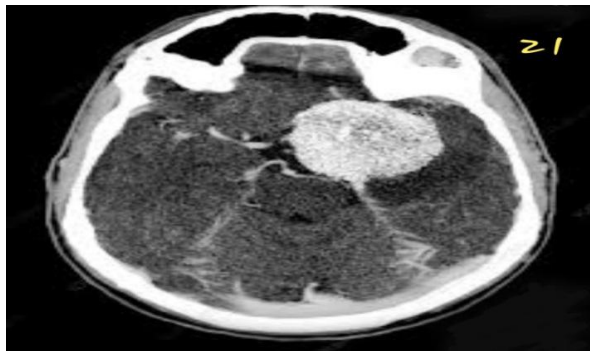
shows an image taken by CT-scan system after giving the patient a contrast agent.
